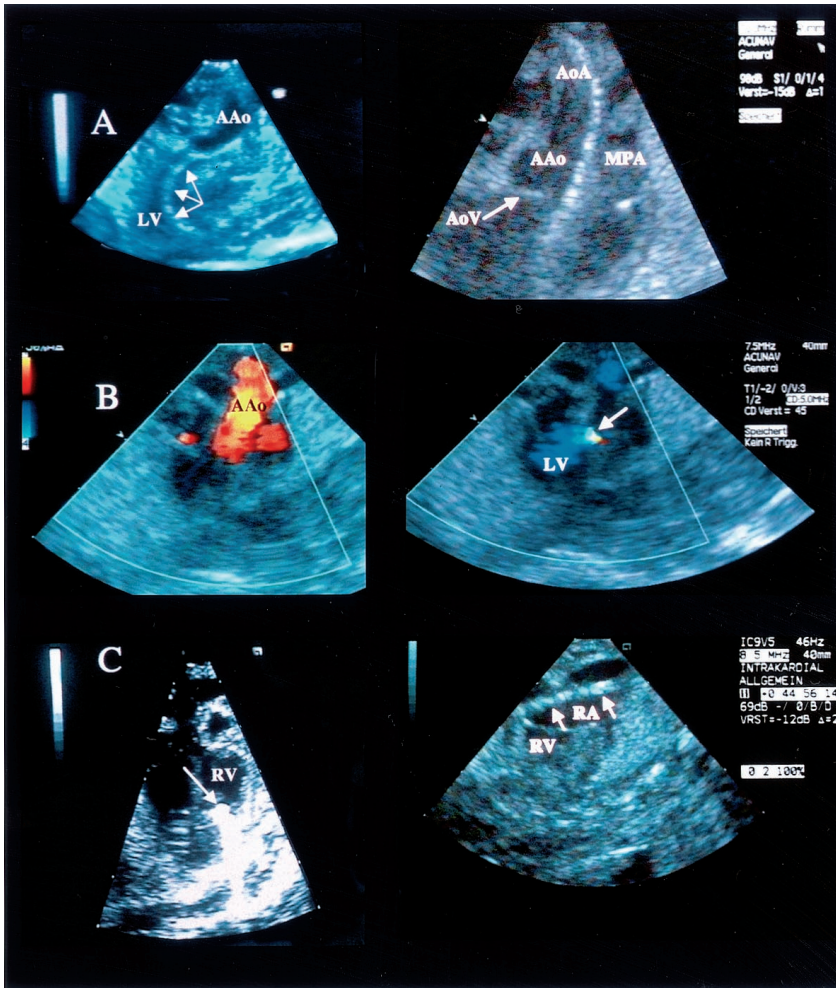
A, Fetal transesophageal imaging using the phased-array intravascular ultrasound catheter for retrograde cardiac catheterization through the umbilical artery. A 0.014-inch guidewire has been placed inside the left ventricle (left; arrows) and above the aortic valve (right). B, Documentation of iatrogenic aortic insufficiency (arrow) after retrograde cardiac catheterization in another fetus (systolic frame on left; diastolic frame on right). C, The high penetration of the catheter also permits visualization of intracardiac insertion of a needle shaft (arrow on left) from the anterior chest for direct transventricular fetal cardiac catheterization (left). In the near field, the catheter permits accurate monitoring of intracardiac insertion of interventional material through the caval veins (arrows on right). AAo indicates ascending aorta; AoA, aortic arch; AoV, aortic valve; MPA, main pulmonary artery; LV, left ventricle; RA, right atrium; and RV, right ventricle.
